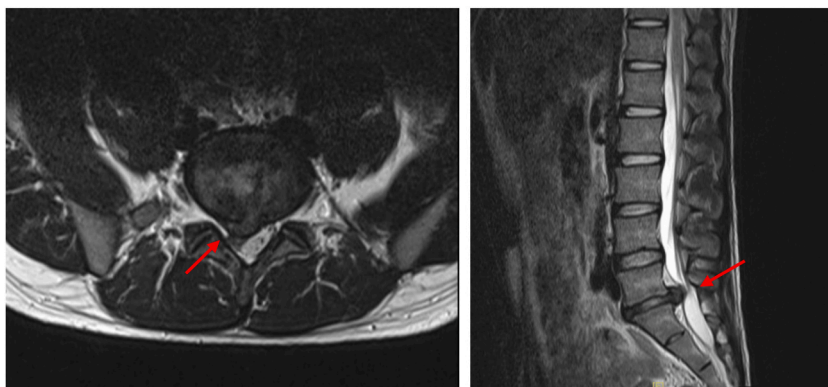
Sagittal (right) and axial (left) T2-weighted MRI of the lumbar spine shows a large, prolapsed disc herniation on the right side at the L5–S1 level (arrows), which caused compression of the S1 nerve root.
